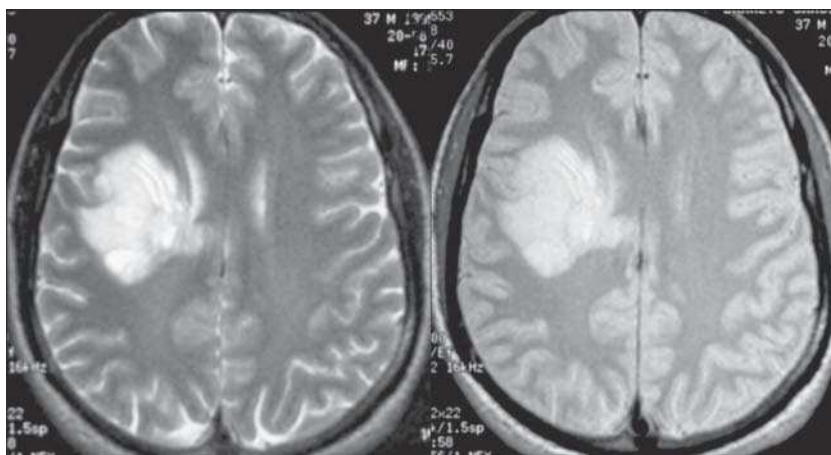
Brain magnetic resonance imaging. T2-weighted sequences (left) and proton density (right) in the transverse plane in a patient with a pseudo-tumoral lesion of demyelinating origin. Note the pattern of concentric bands within the lesion (Baló-type pattern).
